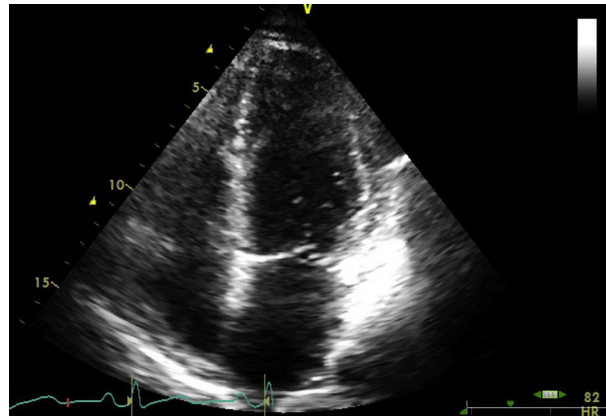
Apical four-chamber view after immunosuppression therapy revealing normal left ventricular size and normal atrial size.
